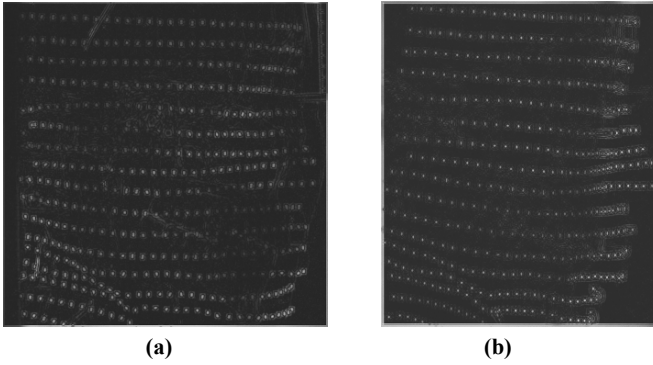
Original X-ray images pair: (a) 60° projection; (b) 90° projection.
